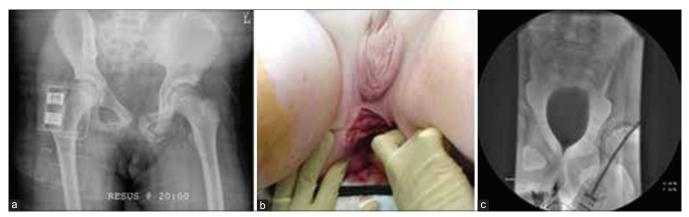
Child involved in a motor vehicle accident. (a and b) X-ray pelvis with both hips anteroposterior view and clinical photograph showing pelvic fracture with perineal injury (c) Cystogram performed to assess urogenital injuries
